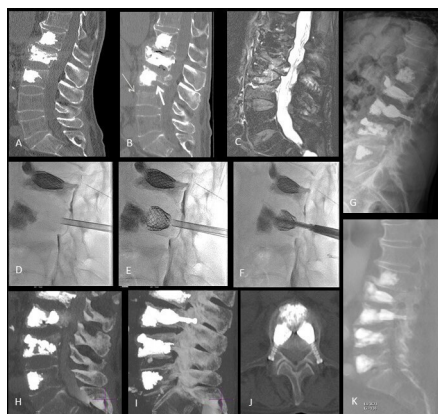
Patient 1. (A) CT scan after stent kyphoplasty of L2 and augmentation of L1 and L3. (B–C) CT scan and MRI at 4 months follow-up showing a collapse of the L3 middle column (thick arrow on B), with posterior wall retropulsion, and a wedge fracture of L4 (thin arrow on B). (D–F) Procedural fluoroscopic lateral views of the modified stent-screw assisted internal fixation (SAIF) of L3: under intraoperative myelography, 4.5 mm bilateral transpedicular trocars are inserted (D), small-size vertebral body stents are inserted and balloon-expanded in the posterior part of the vertebral body (E), and over a k-wire cannulated fenestrated screws are inserted and bone cement is injected (F). (G–J) Post-procedure imaging documentation, with standing plain films (G) and sub-volume maximum intensity projection CT images (H–J), showing partial height restoration of the middle column collapse, and bridging across the middle column and pedicles with the screw-stent-cement complex. (K) Sub-volume sagittal reformatted CT scan at 4 years follow-up, showing stable results at L3, with interval partial compression fracture of L5, which remained asymptomatic.
